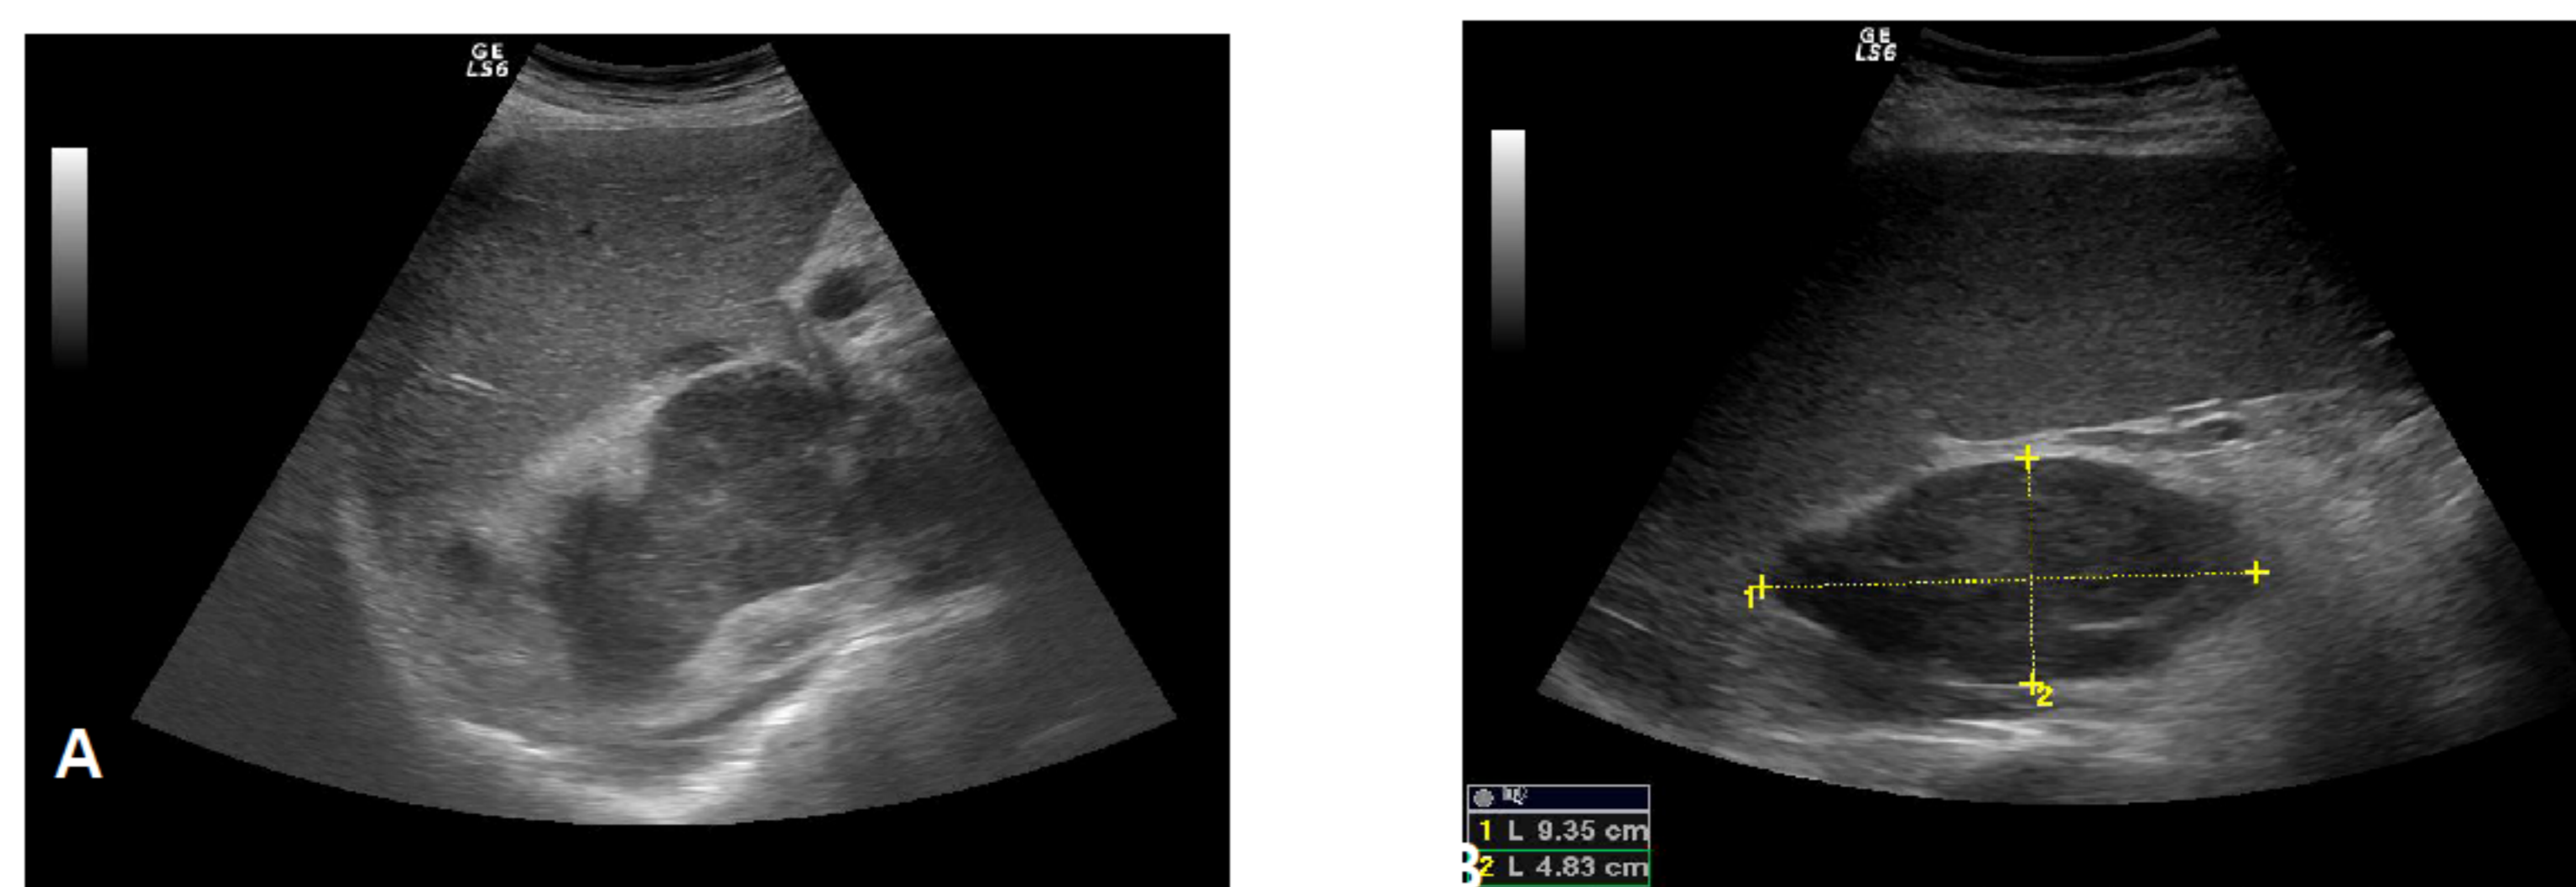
Abdominal ultrasound : A- right adrenal region: bilobate heterogeneous mass, which measured 10/7.5 cm, with increased vascularity, near the inferior caval vein, spreading to the right renal hilum and extending to the liver parenchyma B- left adrenal region: heterogeneous tumora 9.5/4.8 cm, extending to the posterior side.
